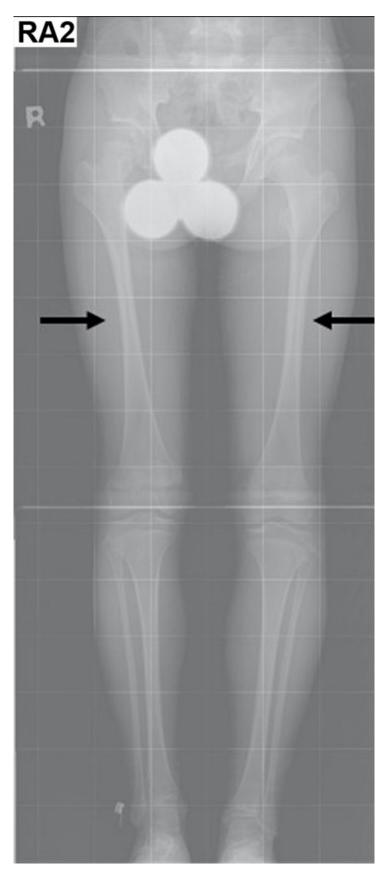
Radiographs of the lower limbs in an individual with Kenny-Caffey syndrome (at age 13 years) showing slender femoral diaphyses with cortical thickening and medullary stenosis (black arrows)
